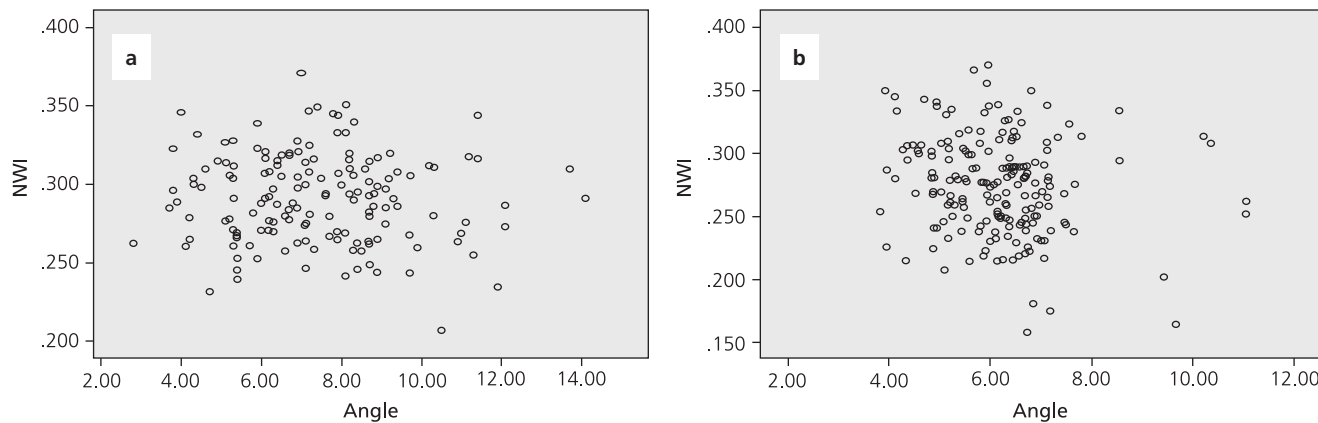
Linear regression of NWI and TEA in (a) bones and (b) MRI images.
